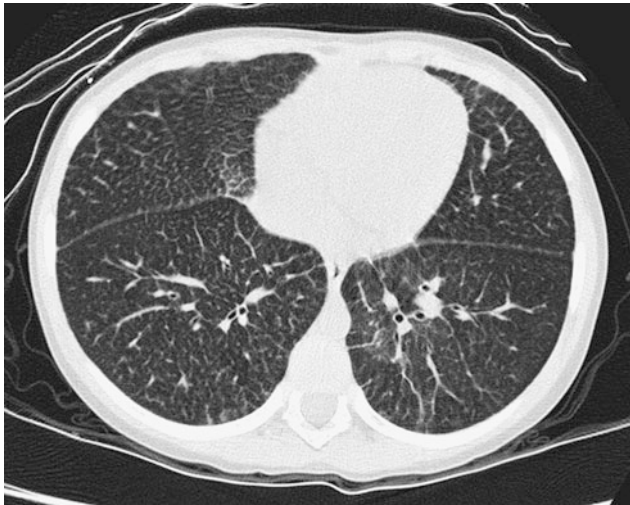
Niemann–Pick disease. An axial chest CT image of a 5-year old with type B disease depicts diffuse septal thickening
